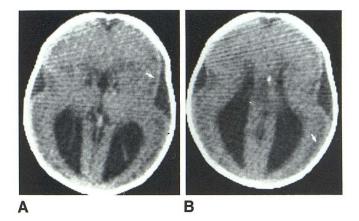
Case 1 (case 1 in [10]). Type I lissencephaly in MDS. A, CT scan at 1 month. B, Higher cut. Typical manifestations of type I lissencephaly and midline calcification. Chromosome analysis demonstrated ring (17) with deletion of part of band 17p13.3. Smooth subsurface line (*arrows*).
